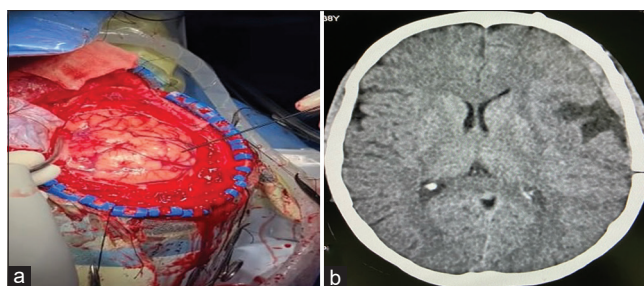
Left-hand image showing tumor lesion being mapped using a monopolar probe (a) and right-hand postoperative computed tomography scan showing total removal of tumor (b)
